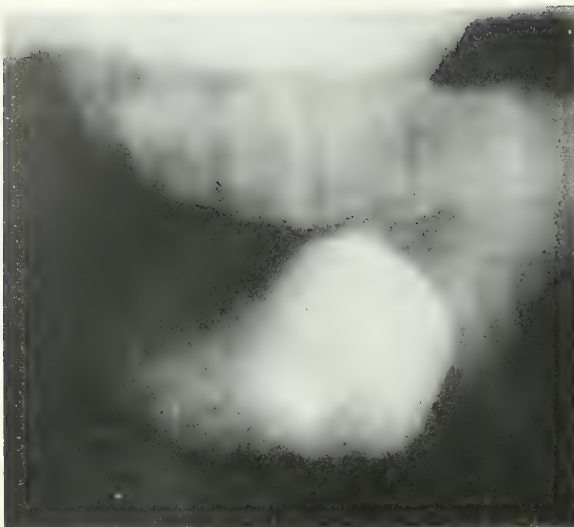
X-ray with barium meal showing the level of the diaphragm on the right side and the full stomach on the left, below the diaphragm.
